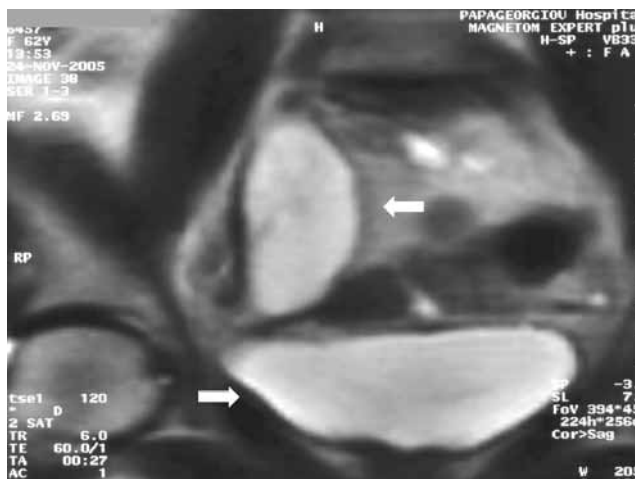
MRI examination showing the cystic mass (top arrow: cystic mass; bottom arrow: urinary bladder).
